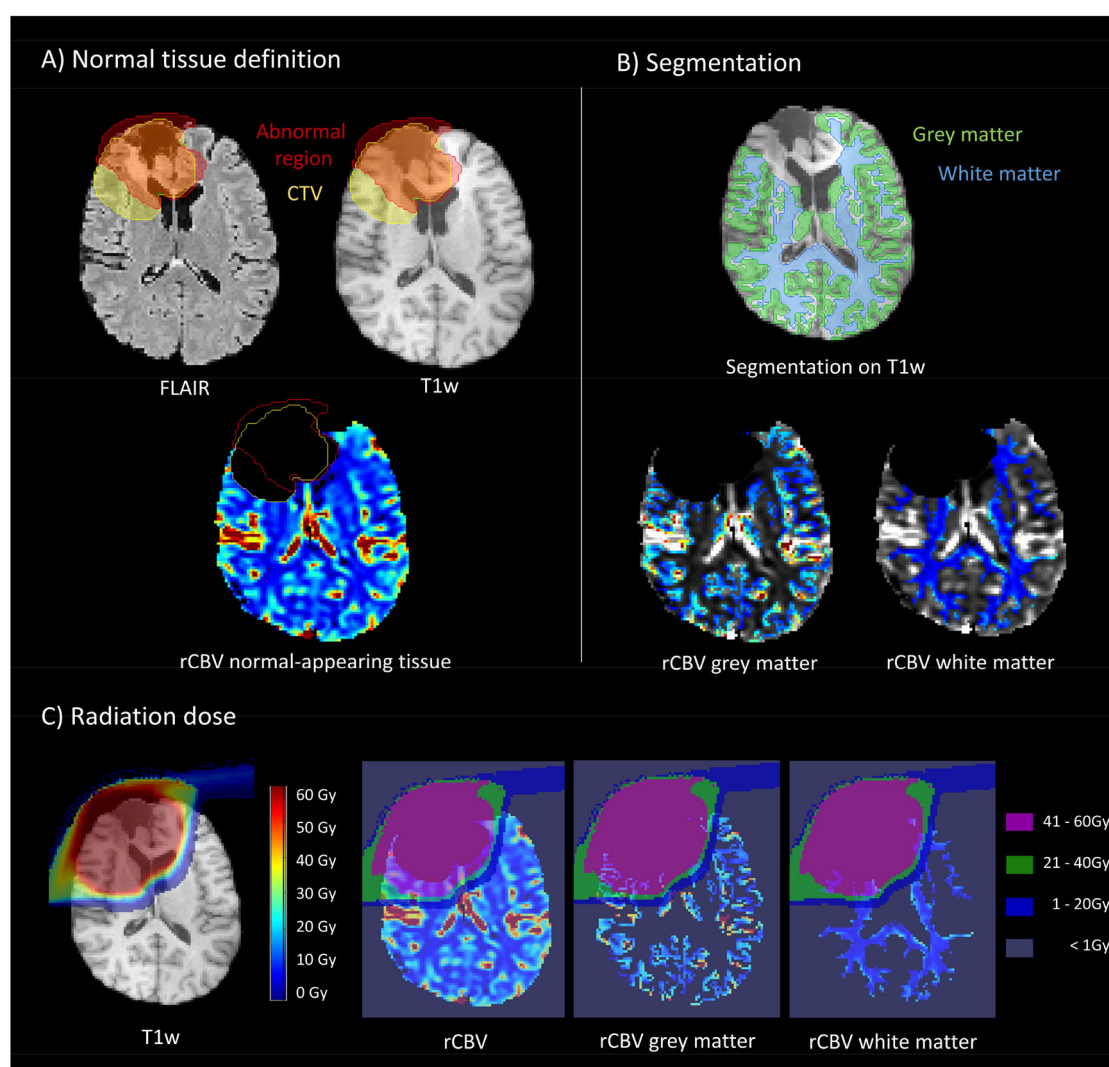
(A) Normal tissue definition by the exclusion of the clinical target volume (CTV) and the areas appearing abnormal on FLAIR imaging. (B) White and grey matter segmentation, defined on T1-weighted (T1w) magnetic resonance imaging (MRI) and registered to relative cerebral blood volume (rCBV) with Advanced Normalisation Tools (ANTs) [24]. (C) Dose distribution of proton irradiation – left: continuous radiation dose distribution, right: dose distribution divided into high dose [41–60 Gy(RBE), pink], intermediate dose [21–40 Gy(RBE), green], low dose [1–20 Gy(RBE), blue] and areas with negligible low radiation dose named “w/o-radiation” – area [<1 Gy(RBE), purple].
